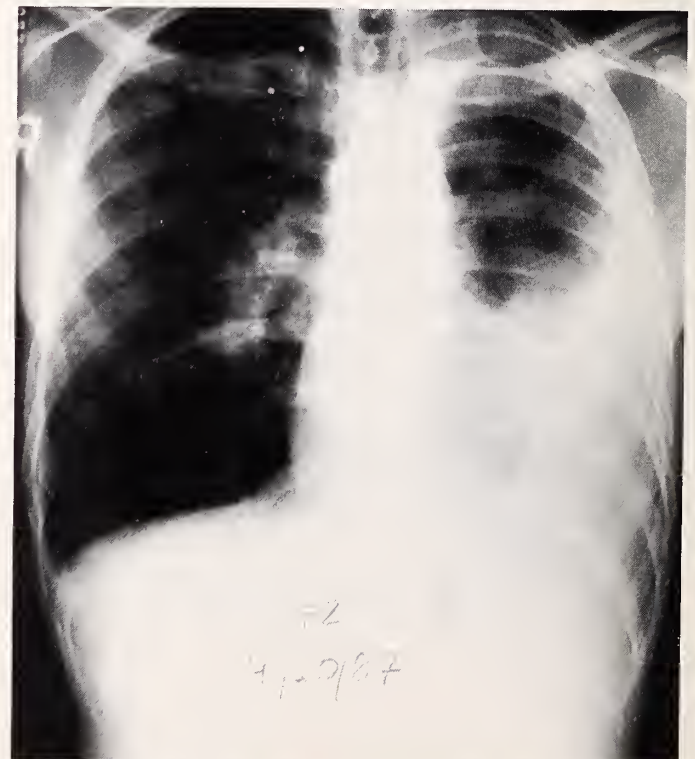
Chest roentgenogram after two months of treatment for tuberculosis.
